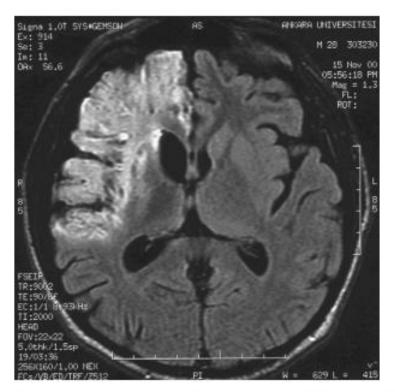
Magnetic resonance image of the brain: focal brain involvement of brucellosis.
